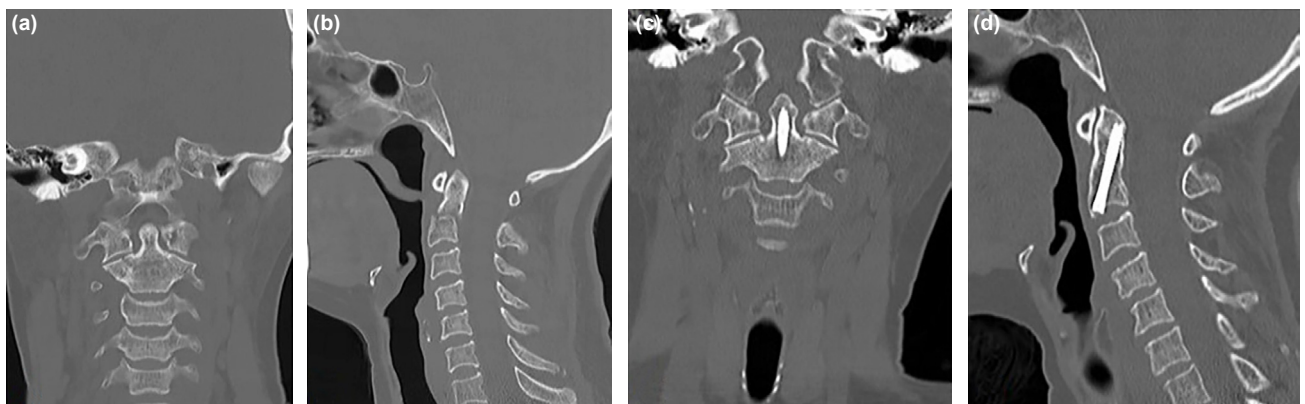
Type III Shallow fracture was seen in coronal and axial CT sections (a, b). Fusion was seen in c and d.
